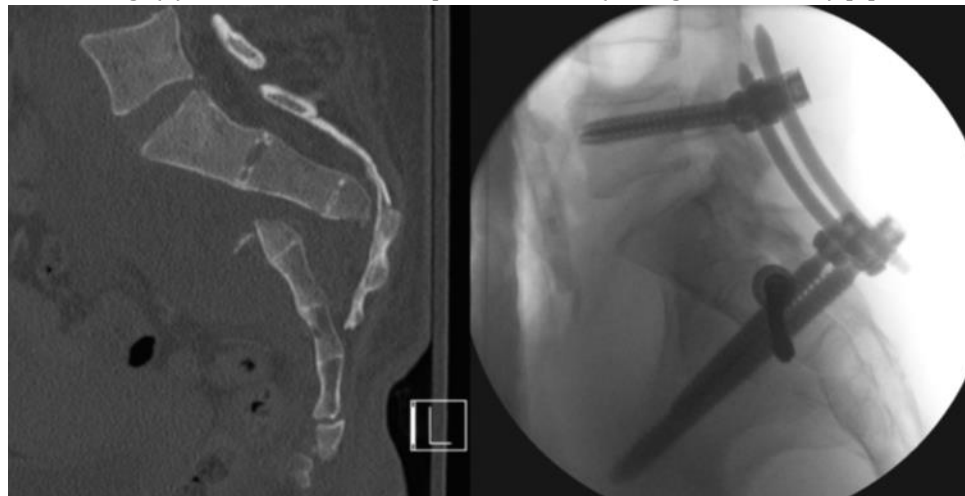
Preoperative CT (left) and intraoperative fluoroscopy (right) demonstrating adequate reduction [13].
